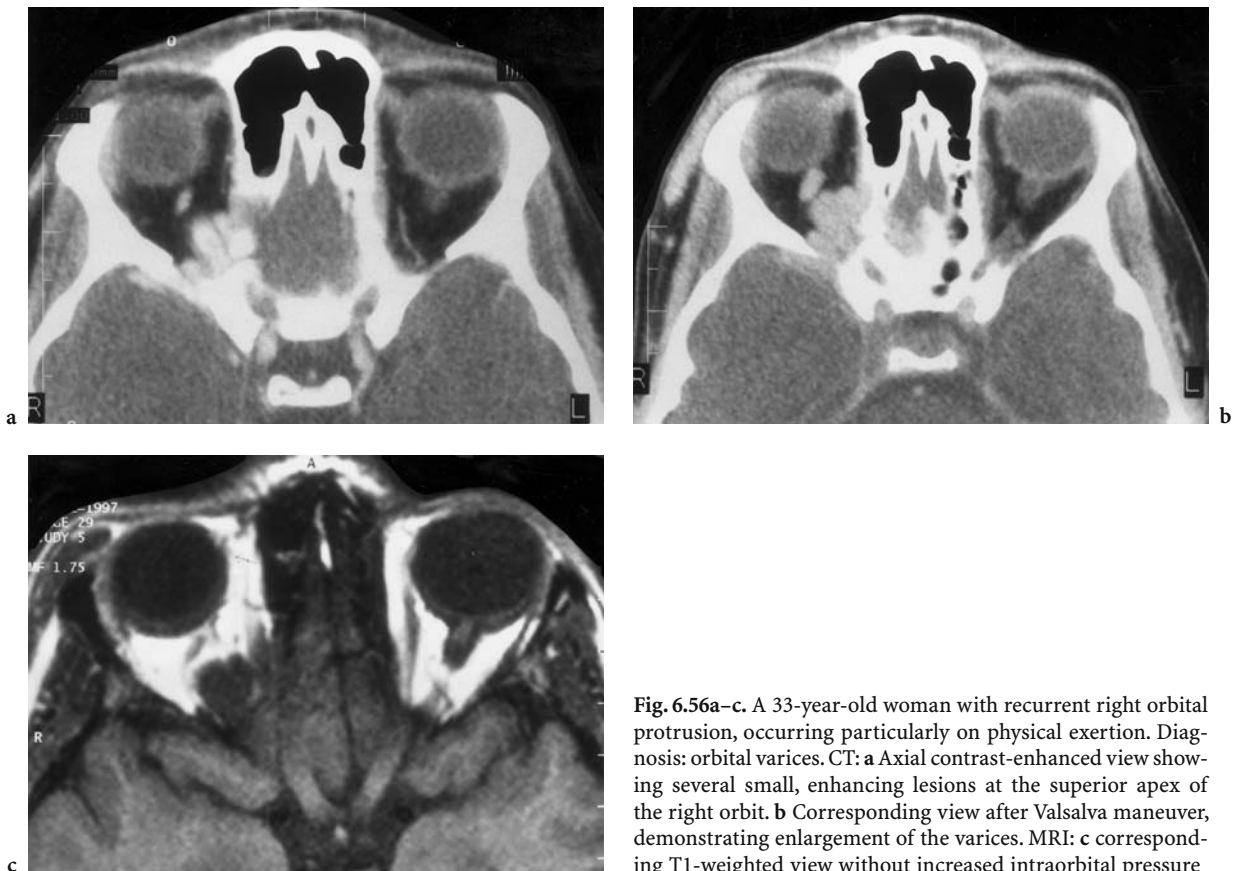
A 33-year-old woman with recurrent right orbital protrusion, occurring particularly on physical exertion. Diagnosis: orbital varices. CT: a Axial contrast-enhanced view showing several small, enhancing lesions at the superior apex of the right orbit. b Corresponding view after Valsalva maneuver, demonstrating enlargement of the varices. MRI: c corresponding T1-weighted view without increased intraorbital pressure
